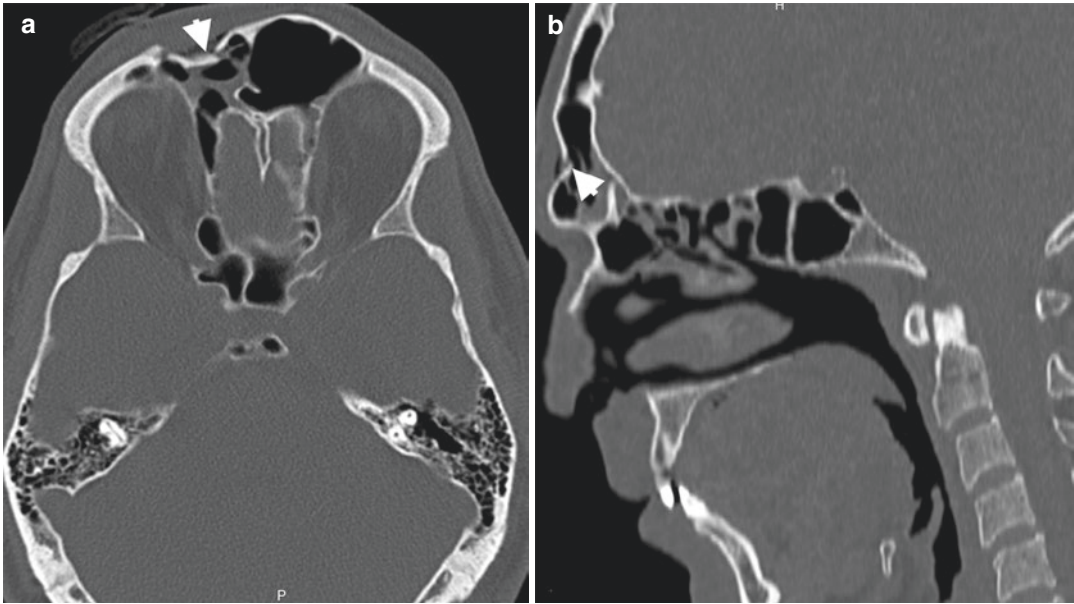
Anterior frontal sinus wall fracture. Axial (a) and sagittal (b) CT images reveal depressed fracture (arrow-heads) of the anterior wall of the frontal sinus
